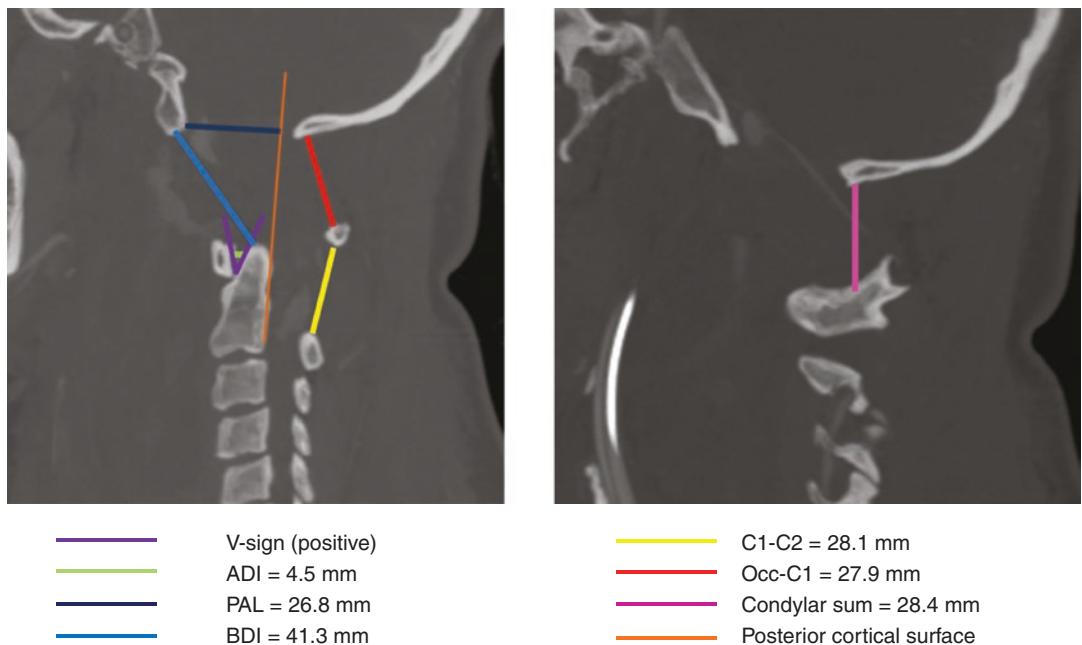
A 56-year-old man involved in a non-lethal high-speed motorcycle collision with craniocervical dissociation. CT cervical spine with sagittal reconstruction plane displaying multiple abnormal measurements. The “V sign” indicates cranially divergent pre dental angle
